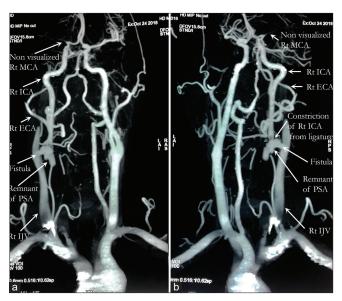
Post operative CTA revealed reduction in size of pseudo aneursysm.
